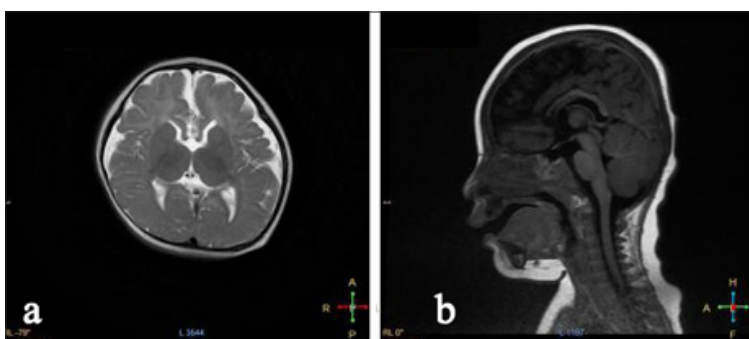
Cerebral MRI a) Sagittal MRI of the brain revealed wide extracerebral space and enlarged frontal gyrus; b) Cerebral coronal MRI displayed hypoplasia of the corpus callosum.
